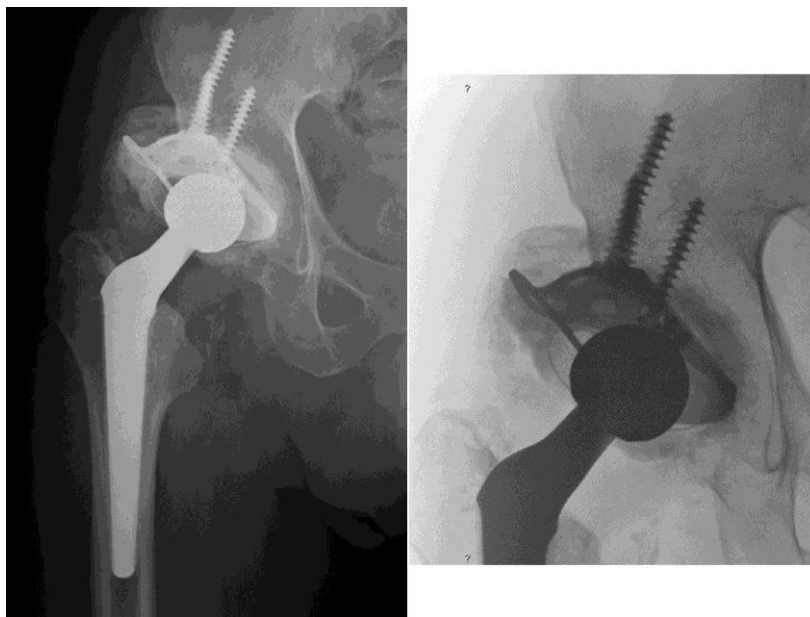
Postoperatively anteroposterior THA radiograph at follow-up period of 1-year. The superolateral portion of the roof reinforcement ring is not covered by the native acetabulum. It is possible to observe the incorporation of impacted morsellized autograft placed between the lateral border of the metal ring and the superior part of the dysplastic acetabulum. No signs of implant instability.
